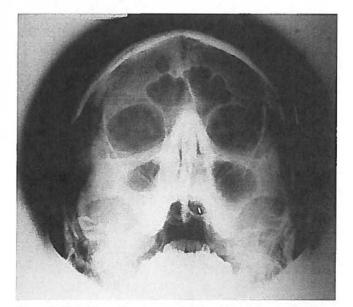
Plain X-ray film showing fluid level in the frontal sinus.
